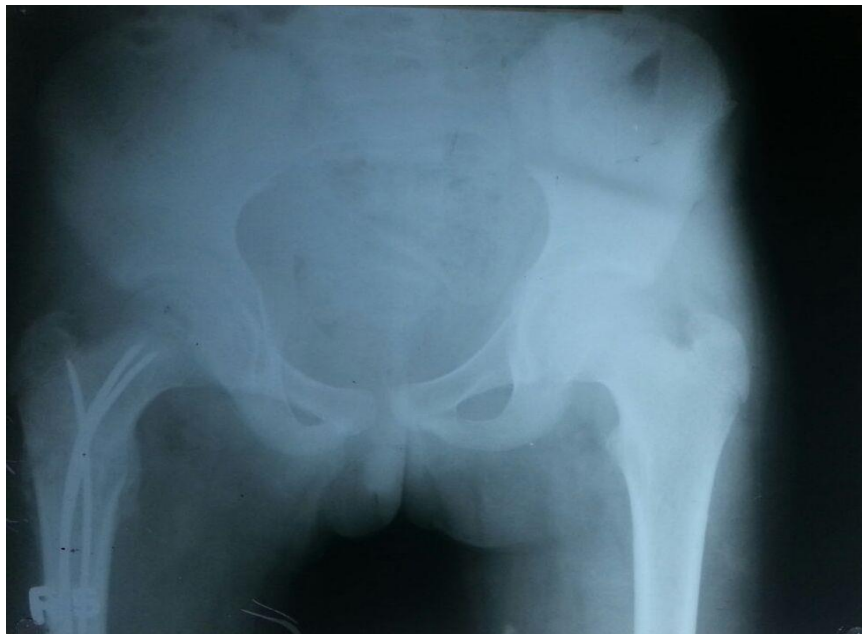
Post-operative x-ray at 2 months of pelvis with both hip showing good callus formation with 3 TENS nails in place
